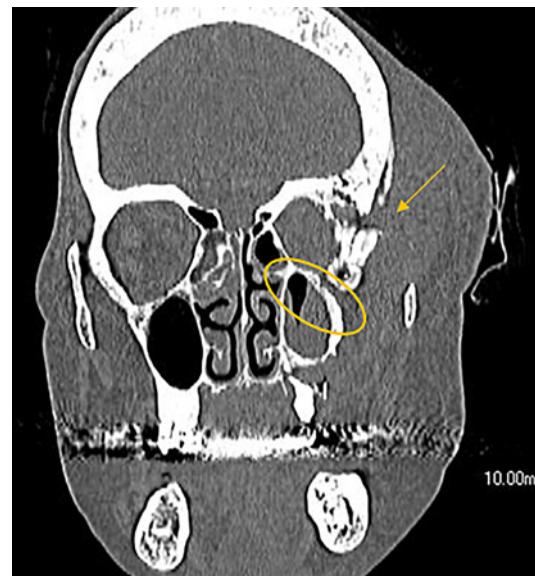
Plain CT image of the orbital region of the head showed bone destruction in the left frontal bone, zygomatic bone, ethmoid bone, and sphenoid bone (arrows). No bone destruction at the border between the maxillary sinus and the orbit (oval) was observed.
